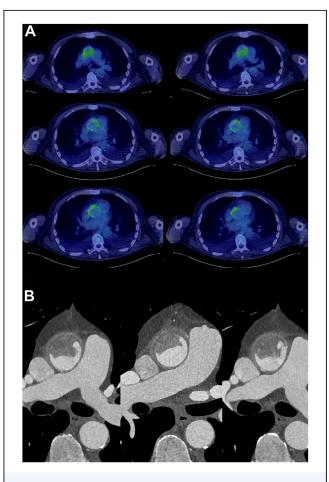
(A) Positron emission tomography scan demonstrating interval increase in diffuse circumferential fluorodeoxyglucose uptake within the ascending aorta. (B) Computed tomography scan demonstrating a ball of fungal mass attached to the proximal suture line of the ascending aortic graft.
